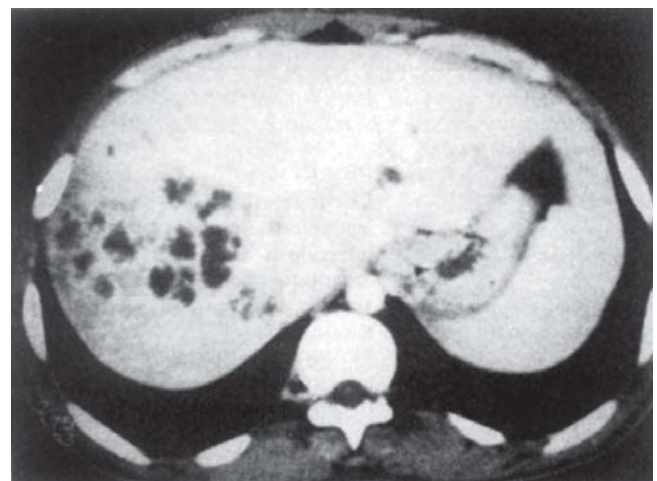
CT scan (contrast enhanced) showing multiple coalescent hypodense areas (right lobe of liver) consistent with pyogenic liver abscesses
